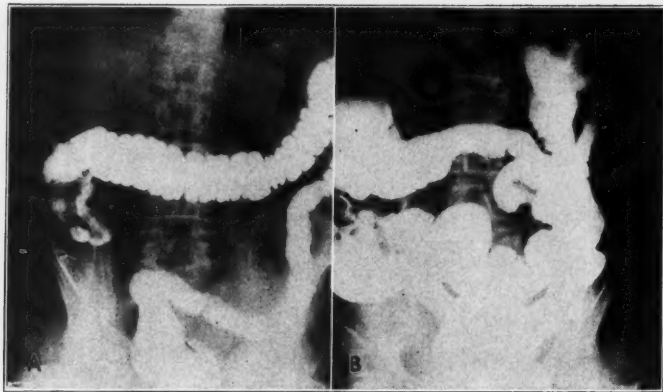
(A) Roentgenogram showing a filling defect in the cecum due to carcinoma. (B) Roentgenogram showing a filling defect in the ascending colon due to a large carcinoma.
